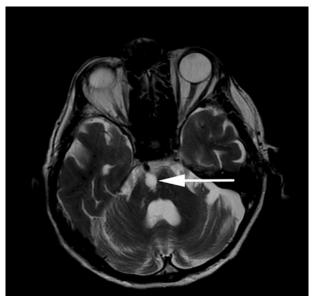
Axial T2-weighted (a) and FLAIR (b) images depict pontine lacunar infarct (arrow) in the area of trigeminal and abducens nerve nuclei in a 78-year-old man
